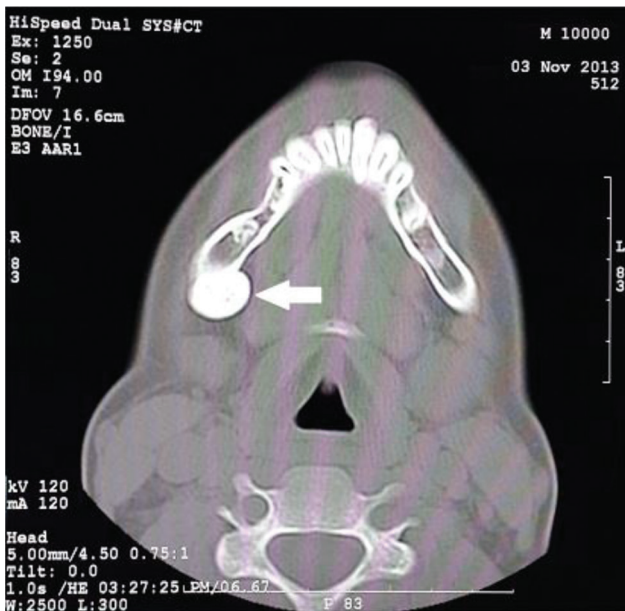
CT scan showing 1 x 1.3 cm, well-defined, rounded osteoma at the inferior surface of the right mandible.
